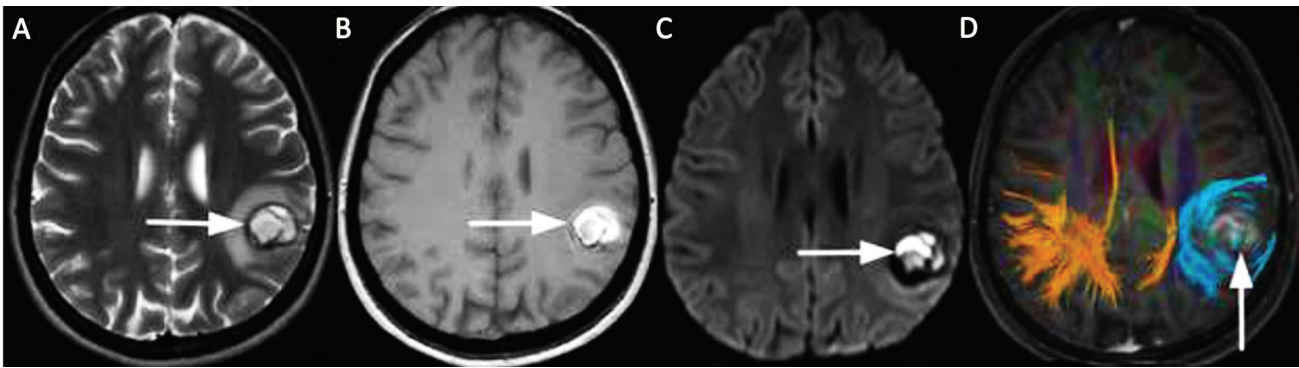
A left parietal lobe cavernous malformation (CM) in a 25-year-old female patient with seizure. (A) There is a heterogeneous hyperintense lesion with peripheral hypointense rim (*arrow*) and perilesional edema on axial T2-weighted magnetic resonance (MR) image. (B) The lesion shows hyperintense signals on axial T1-weighted MR image, with T1 perilesional hyperintense sign (*arrow*). (C) There is restricted diffusion as hyperintense signals on diffusion-weighted imaging (DWI; *arrow*) and hypointense signals on the corresponding apparent diffusion coefficient (ADC) map (not shown) due to subacute hemorrhage. (D) Diffusion tensor imaging tractography for preoperative planning demonstrates the benign displacement of subcortical white matter fiber tracts (*arrow*).
